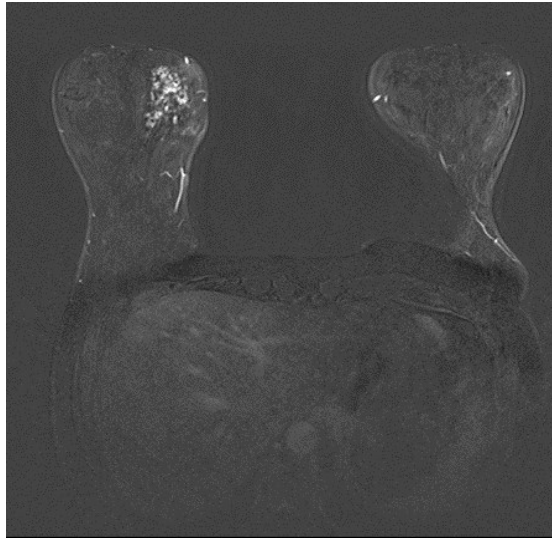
MRI of the same patient with non-mass enhancement on postcontrast subtraction image.
